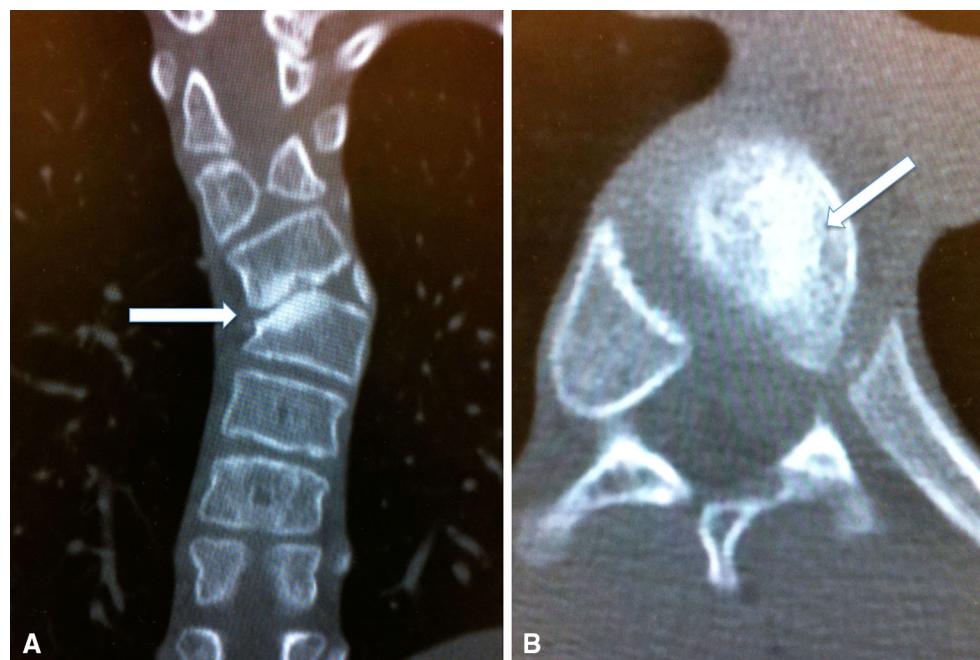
Computed tomography of entire spine in coronal and axial views showed fully segmented hemivertebrae at T7 with disc space narrowing and sclerosis (*arrow*) at left lower endplate of T6 and left
